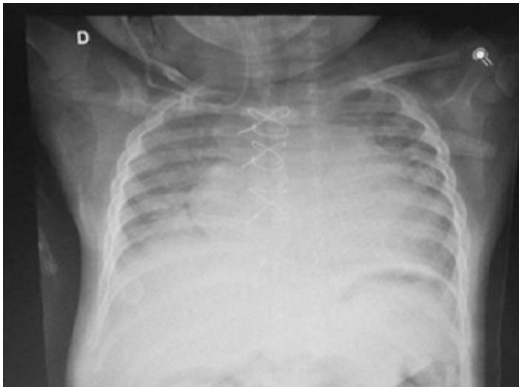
Chest X-ray after surgical treatment. Considerable reduced size of right atrium and pulmonary congestion is observed
